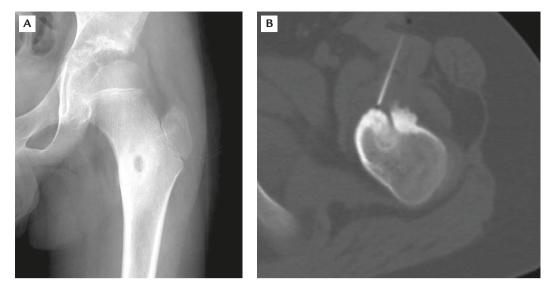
An 11-year-old boy with recurrent osteoid osteoma involving the proximal femur: (A) radiograph; (B) computed tomography (CT) scan. It is difficult to distinguish the nidus from the old drilling hole by plain radiography, but the CT scan clearly demonstrates these 2 entities.
